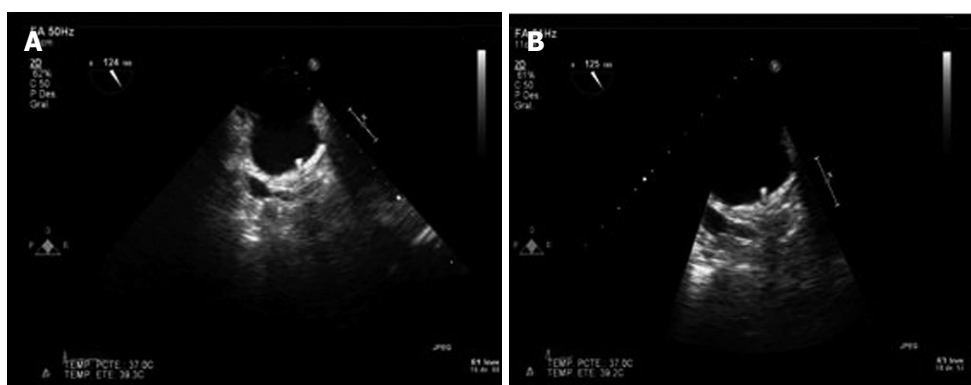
Transesophageal echocardiography two-dimensional image. A: Control after 2 wk of intravenous sodium heparin treatment. Complete resolution of button thrombosis and correct device positioning; B: 6 mo control. Correct device positioning and absence of button thrombosis.
